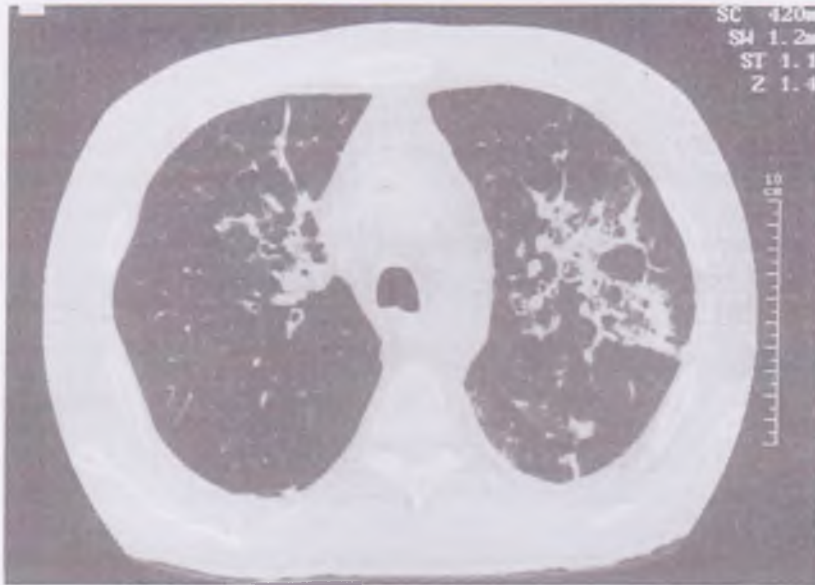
CT scan appearance of the midzones of an allogeneic BMT patient with diffuse pulmonary aspergillosis.
